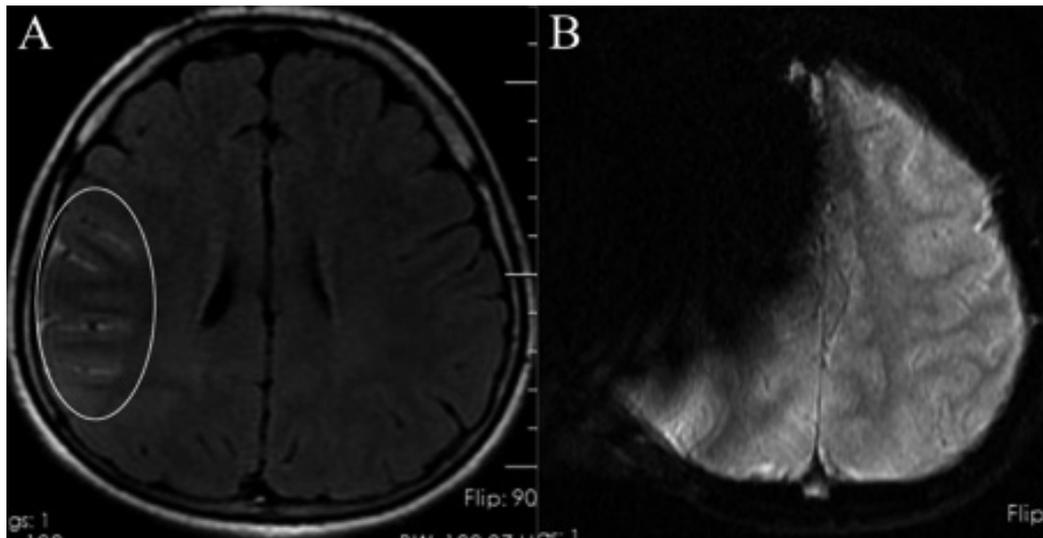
Pseudo-SAH appearance secondary to conductive EEG gel. A, On MRI, FLAIR image shows sulcal hyperintensities in the right frontoparietal region (ellipse). B, Extensive magnetic susceptibility artifact is present in the right frontal region on SWI images.
